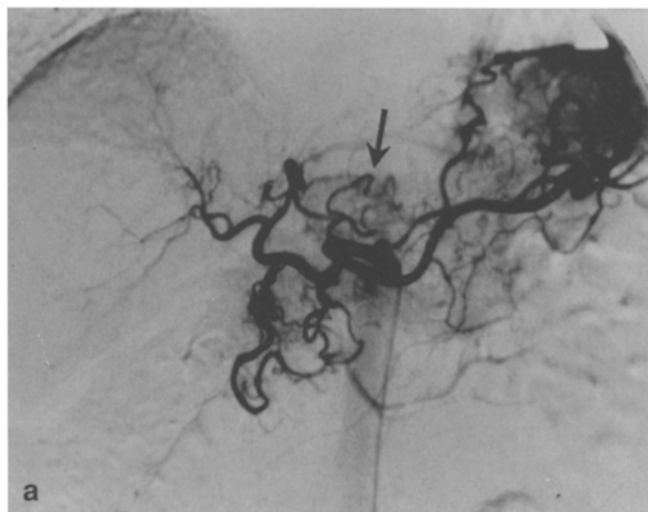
(a) A small HCC nodule fed by a lateral inferior subsegmental artery is demonstrated on DSA (arrow). (b) A microcatheter was inserted into the feeding subsegmental artery, and TAE was performed with a mixture of ethanol and Lipiodol (arrow). (c) CT before TAE
